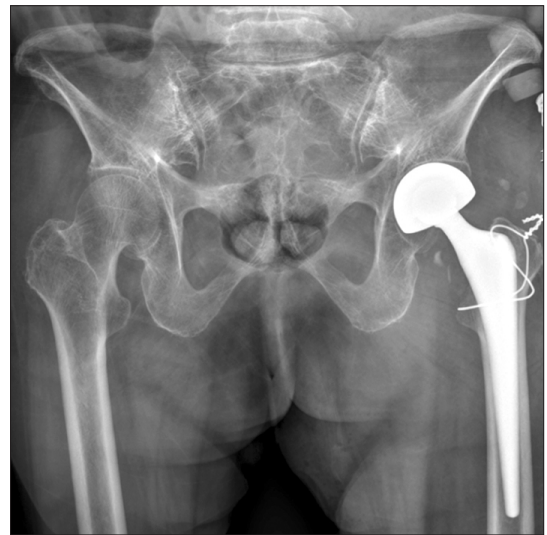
The tip-to-stem distance was measured on the plain radiograph.
